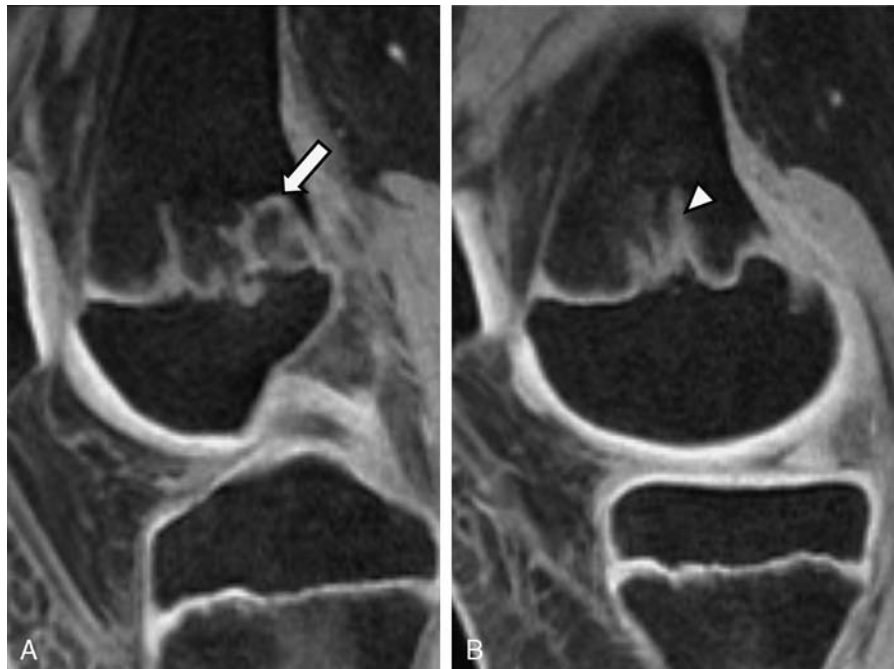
Sagittal fat-suppressed 3-dimensional spoiled gradient recalled echo sequences magnetic resonance images in a 13-year-old adolescent with a prior Salter-Harris IV fracture of the distal femur demonstrating metaphyseal intrusions as (A) bars of cartilage signal intensity within the metaphysis (arrow); (B) direct extensions of cartilage from the physis (arrowhead).
